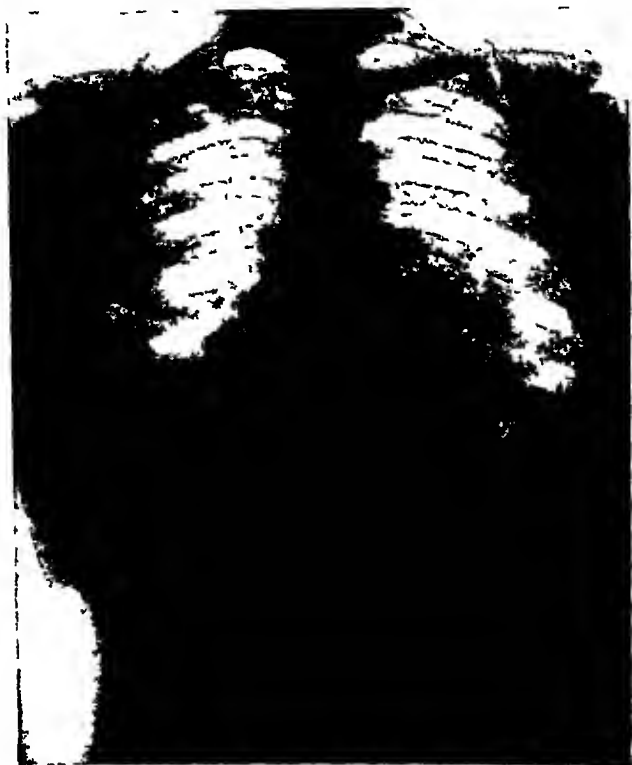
Case III. x-Ray taken on August 20, 1924. There is an extension of the lesion over the left base. The pleural effusion is still present.
